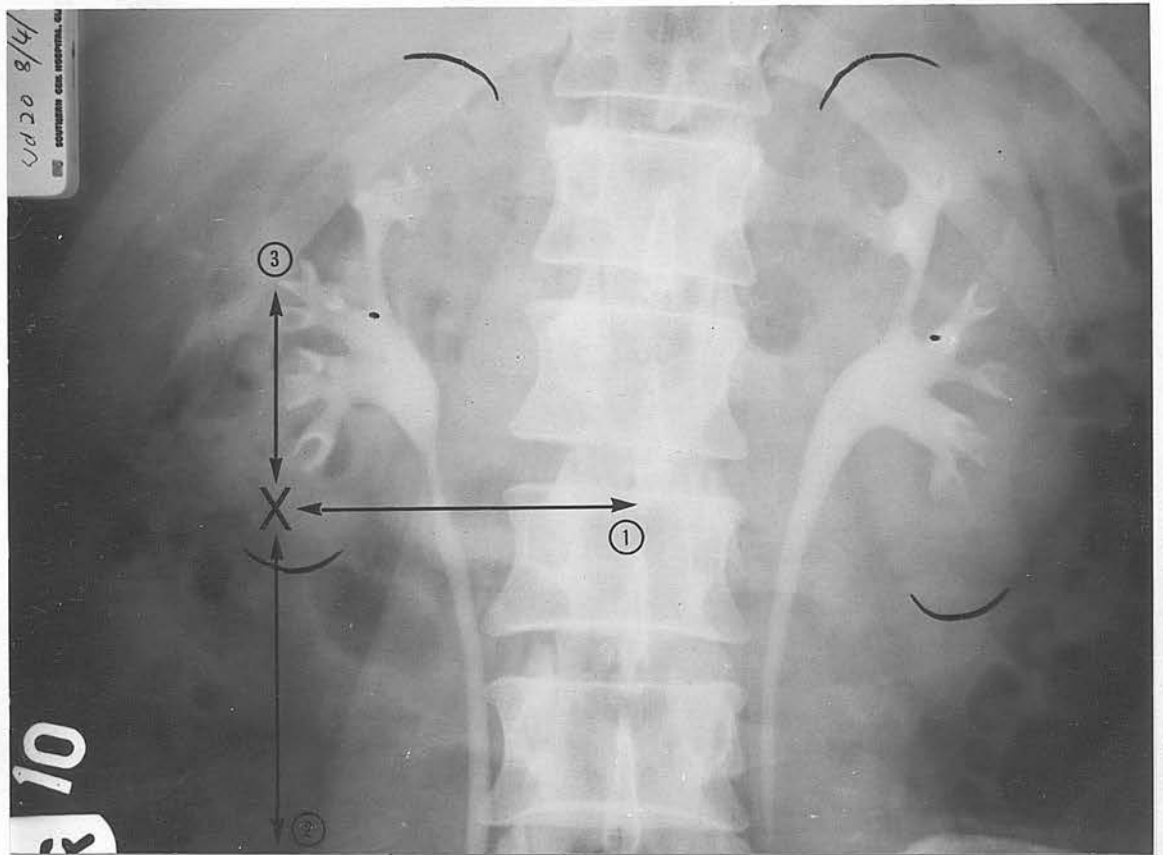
X-Ray of intravenous pyelogram. Point X in cortex of lower pole of right kidney. 1, 2 and 3: measurements from X to lumbar spinous processes, iliac crest and 12th right rib respectively.
